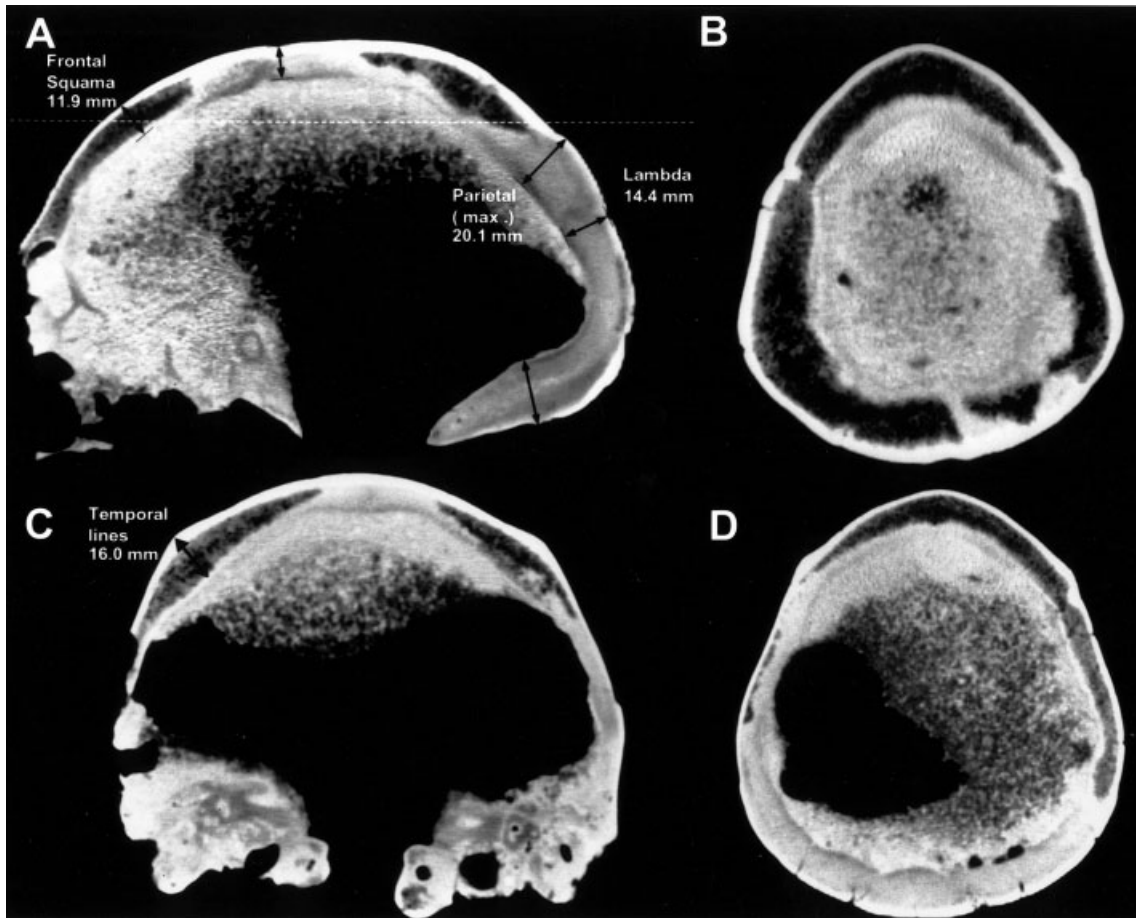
A, C: Midsagittal and coronal CT scans show thickening of KMN-ES 11693 vault. Diploic layer of posterior parietals and occipital is completely saturated by matrix. Thickness at various points is displayed, also showing that widening is not restricted to fronto-parietal enlargement. B: Transversal CT scan (level as indicated in A by dotted line) reveals a homogeneous thickening of diploic space. In left part of parietals, diploic layer displays incomplete saturation by matrix. D: Transversal scan taken above frontal sinus and parallel to orbito-meatal plane.
